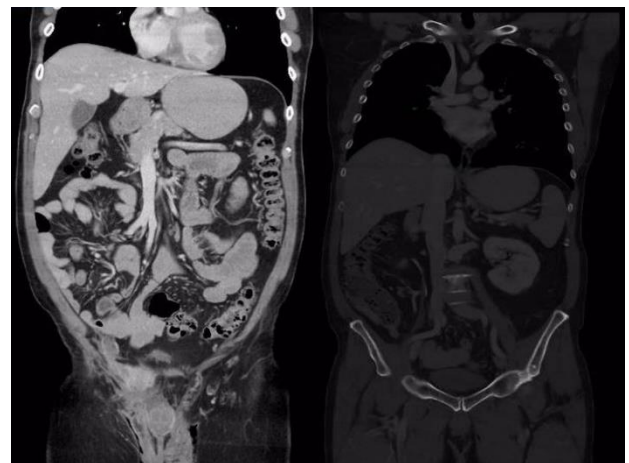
PET/CT scan with 18F-FDG where we can see a hypermetabolic lesion with SUVmax of 3.1 and diameter of 33x32mm.
